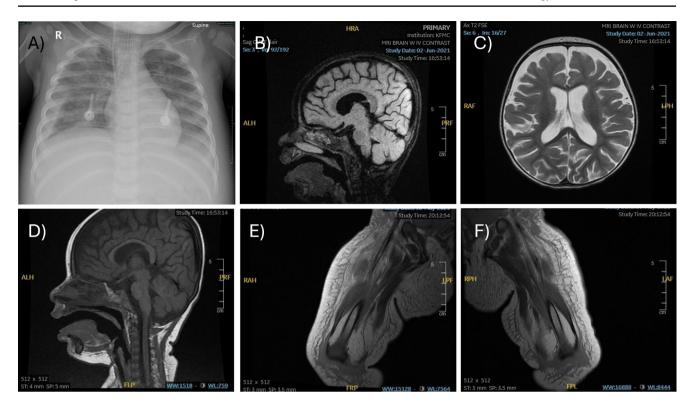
a) Chest x-ray b-d) Brain MRI shows mild global brain volume loss with mild chronic hydrocephalus. No signs for active encephalitis, meningoencephalitis, or meningitis. e-f) Necrotic lesion of the left
